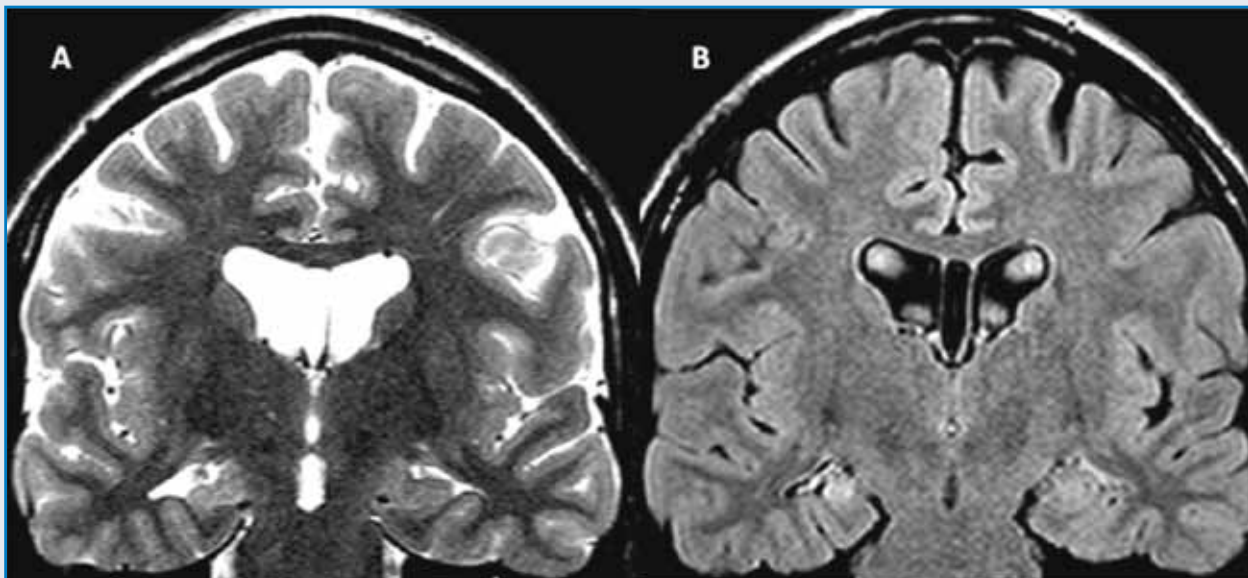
Mapping spatial memory in a patient with hippocampus sclerosis and epilepsy. Figure 3a: A – coronal T2-weighted and B – coronal FLAIR sequences showing sclerotic hippocampus on the right. R – right, L – left.
